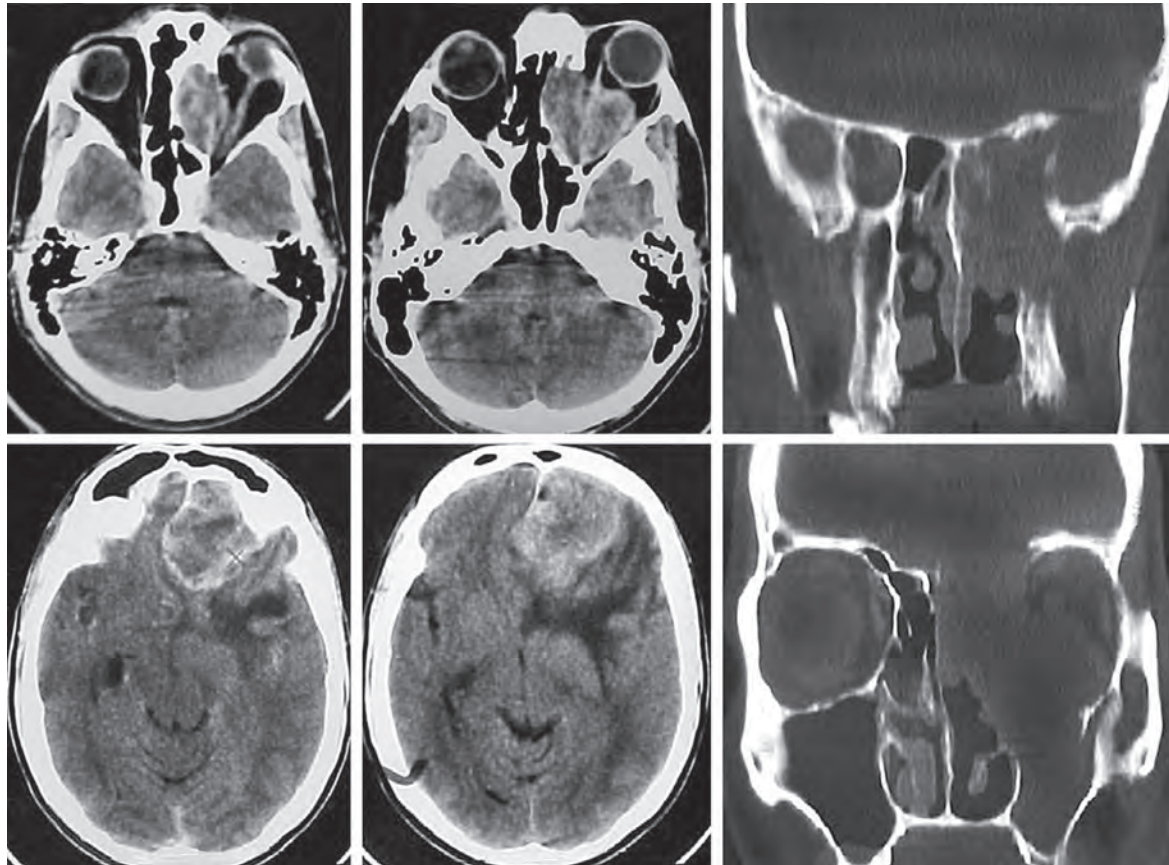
CT of the brain showing infection in the maxillary and ethmoidal sinuses with extension into the orbit. There is evidence of erosion of the skull base and spread to brain parenchyma with perilesional oedema (Stage IIIB)
